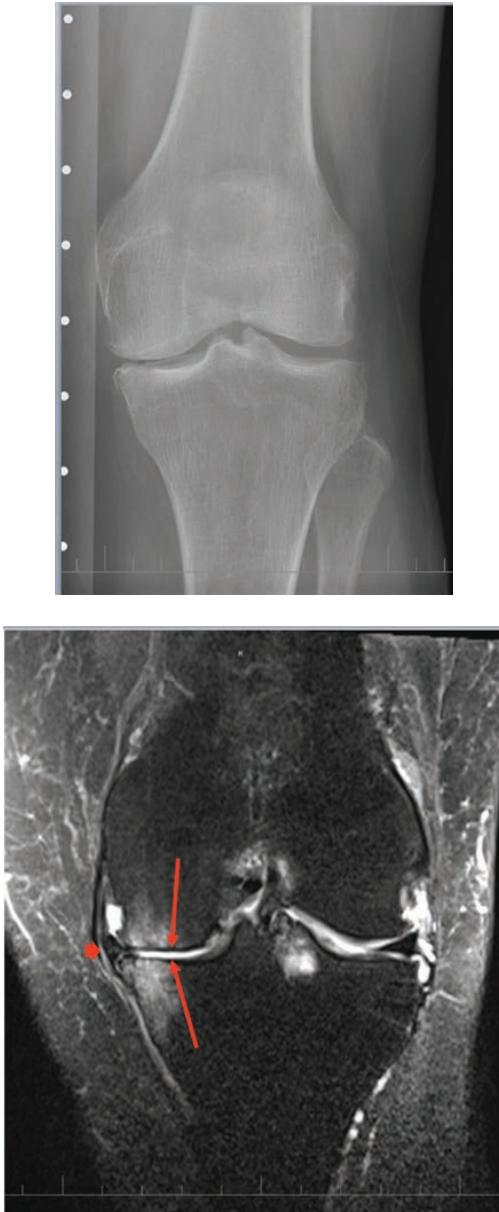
X-ray and MRI of knee with medial osteoarthritis. X-ray shows osteophytes at the medial and lateral tibia and femur and joint space narrowing of the medial tibiofemoral joint. Coronal intermediate-weighted fat-suppressed MRI confirms the presence of medial and lateral osteophytes and the medial tibiofemoral joint space narrowing. There is diffuse denuded area with no cartilage remaining at the weight-bearing medial tibiofemoral joint (arrows). There is also a severe medial meniscus extrusion (arrowhead). Bone marrow lesions, which provide evidence of bone injury, are present at medial tibia, medial femur, and intraspinous tibial region. Cartilage focal defects are also seen at the lateral weight-bearing femur and tibia.
